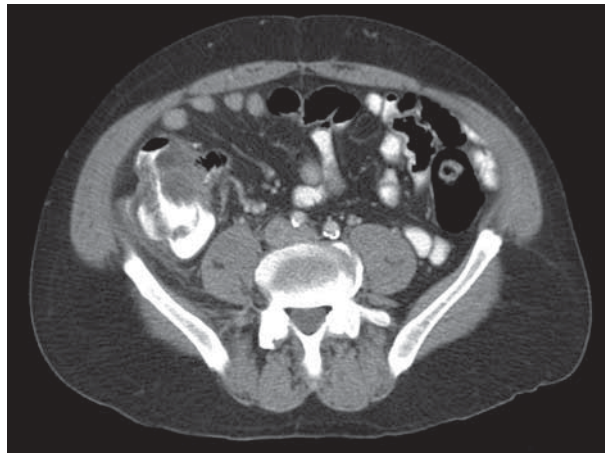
Abdominal computed tomography shows a contrast-containing 4.4 × 6.6-cm mass in the right lower quadrant with inflammatory changes surrounding the inferior aspect.
